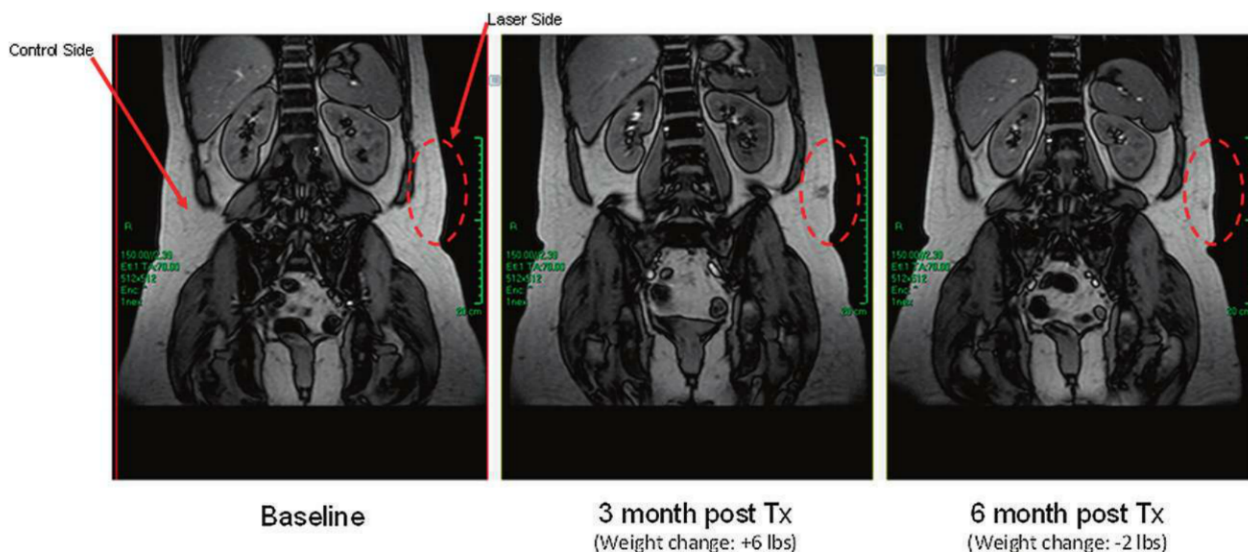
Examples of fat thickness changes demonstrated by MRI.
